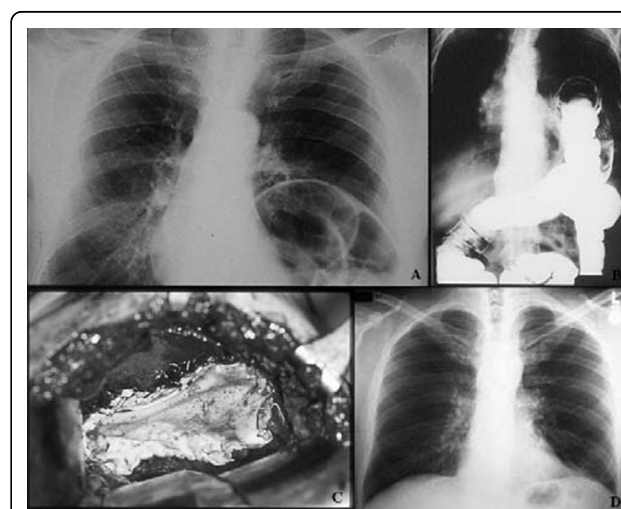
Features of the left diaphragmatic agenesis and positioning of the prosthesis. A) detail of chest x-ray showing the bowel herniation into the left hemithorax; B) contrast medium x-ray enema showing herniation of the colon into the left thoracic cavity; C) intraoperative picture showing left diaphragmatic agenesis and the e-PTFE Gore-Tex® patch in place; D) postoperative standard chest x-ray showing correct position of the new prosthetic diaphragmatic dome.
